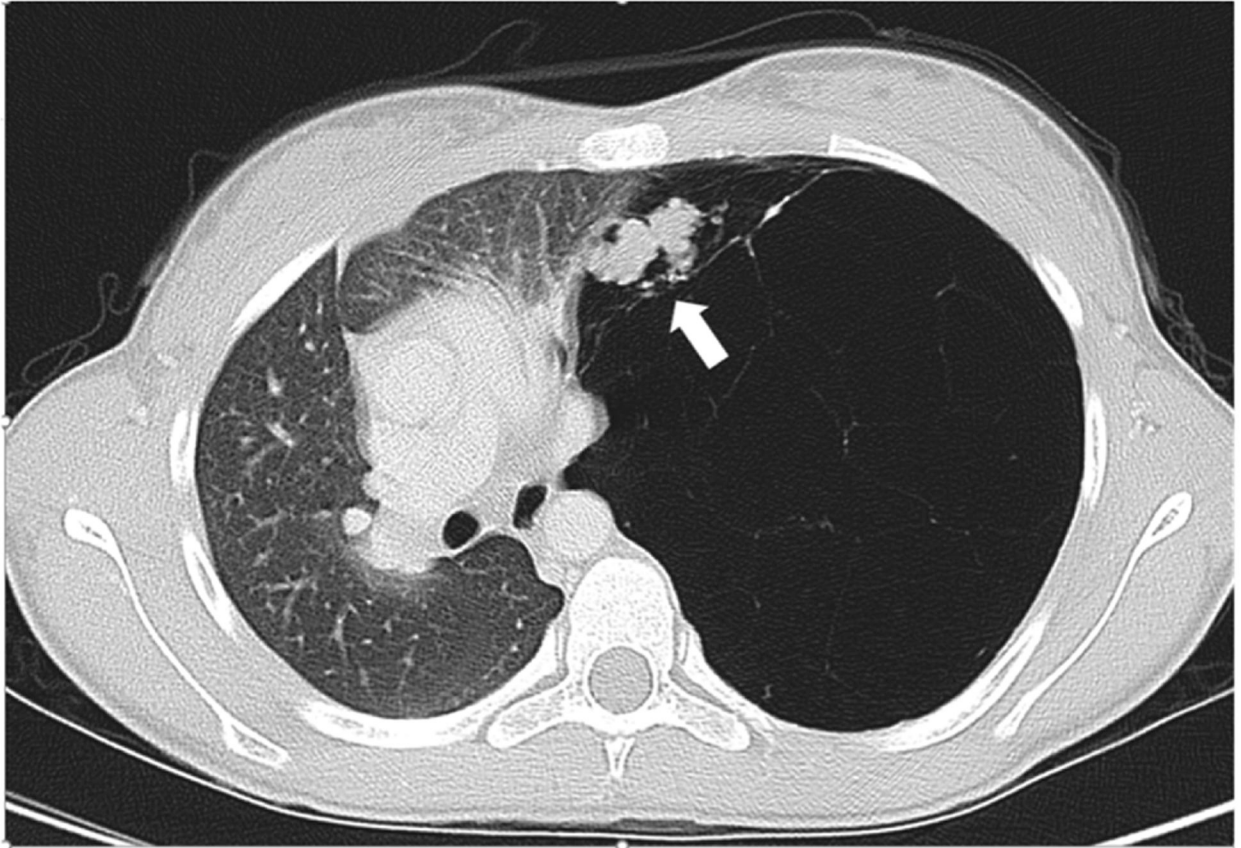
Axial CT of the chest lung window Large cystic lesion with internal thin septations exerting marked mass effect and secondary rightward mediastinal shift An internal single lobulated solid nodule (white arrow) raised the concern for a potential underlying neoplasm.
